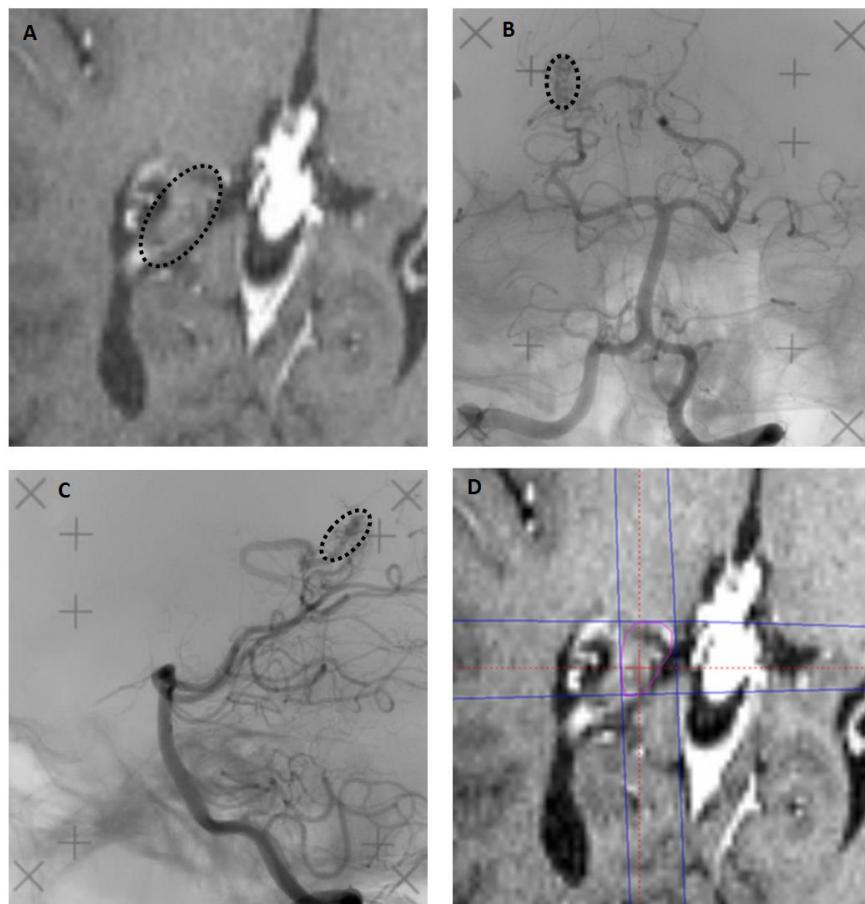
(A) Postcontrast T1 weighted MRI with a depiction of AVM target without interventional cerebral arteriography (B) Anterior-posterior (AP) and (C) right-left (RL) fluoroscopic images from cerebral arteriography used for nidus identification. X and + marks of the stereotactic frame depicted on these images enable fusion with MRI. (D) Fused MRI showing 2D nidus location from (B) and (C) projected as blue lines to delineate the nidus as target (pink outline).
